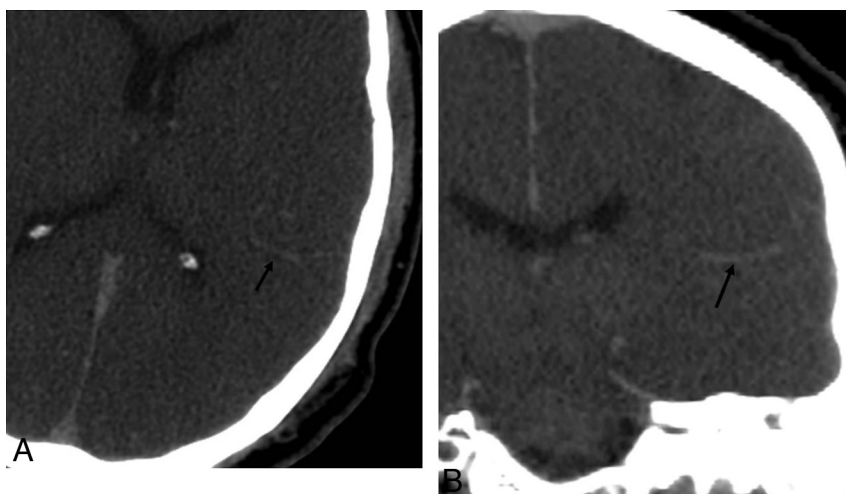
Hyperattenuating vein. Axial (*A*) and coronal reformat (*B*) noncontrast CT demonstrates a hyperattenuating vein in the left tempoparietal region (arrows). This should not be mistaken for subarachnoid hemorrhage.
